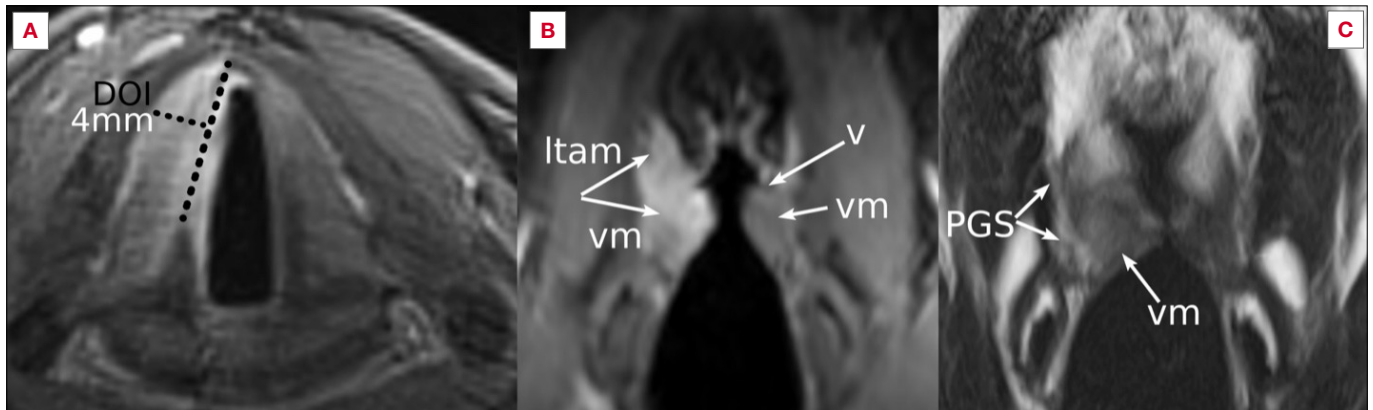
A) Post-contrast magnetic resonance (MR) imaging at the level of the glottic plane of a cT2 with impaired vocal cord mobility. A dotted line is drawn from the vocal process of the right arytenoid cartilage to the anterior commissure. Depth of invasion (DOI) is measured along an orthogonal segment and involves the full thickness of the vocalis muscle; B) Coronal post-contrast MR. The entire thyroarytenoid muscle – including both the lateral thyroarytenoid (ltam) and vocalis muscles (vm) – is involved. On the contralateral side, the normal vm and ventricle (v) are visible; C) Coronal MR T2-weighted image demonstrating altered signal of the vm (more hyperintense compared to the contralateral side). Note that the fat of the para-glottic space (PGS) is preserved and appears enlarged compared to the contralateral side, consistent with oedema.
